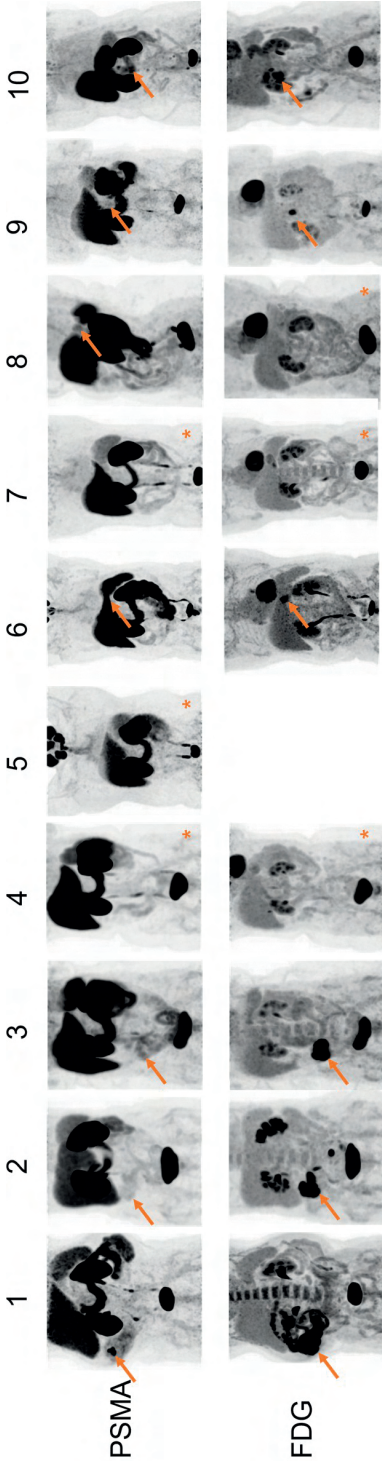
Maximum Intensity Projection (MIP) PET images of all included patients. The arrows indicate the location of the primary tumour. In the MIP PET images with an asterisk the primary tumour was not visible. [¹⁸F]FDG PET/CT of patient 5 was not performed as this was not the standard of care due to his cT2-3 gastric tumour. Patient numbers are identical to Table 1.
